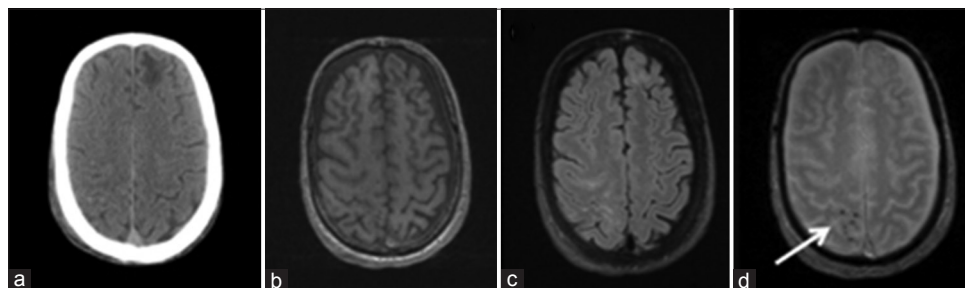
(a) Computed tomography showing chronic left frontal encephalomalacia, but no acute intracranial blood. (b) T1-magnetization prepared rapid gradient echo unremarkable. (c) Fluid-attenuated inversion recovery revealing right frontoparietal hyperintensity. (d) T2-gradient recall echo showing punctate pre and post-central intraparenchymal hemorrhage (white arrow)
